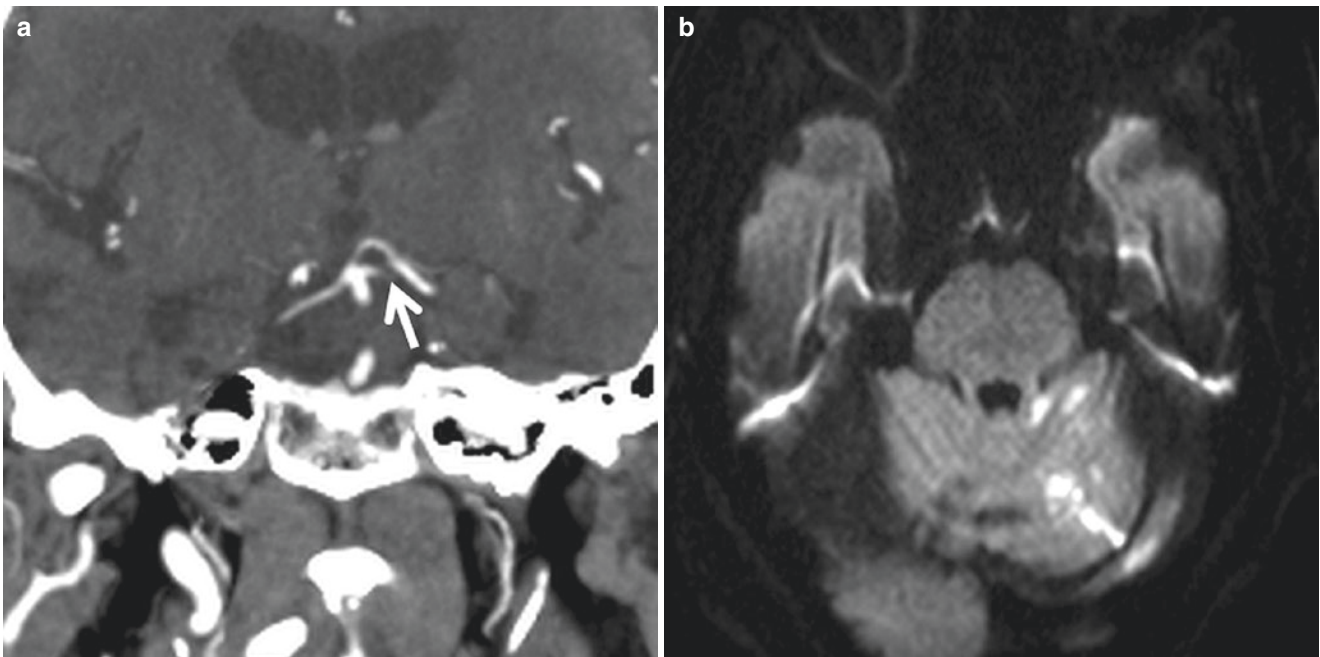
Superior cerebellar artery infarction. (a), Coronal CTA MIP demonstrates occlusion of the left SCA at the origin (arrow). (b), DWI shows acute infarction in the left superior cerebellum
